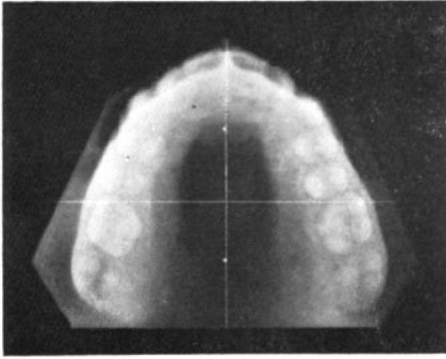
X-ray of plaster model as suggested by Downs.
